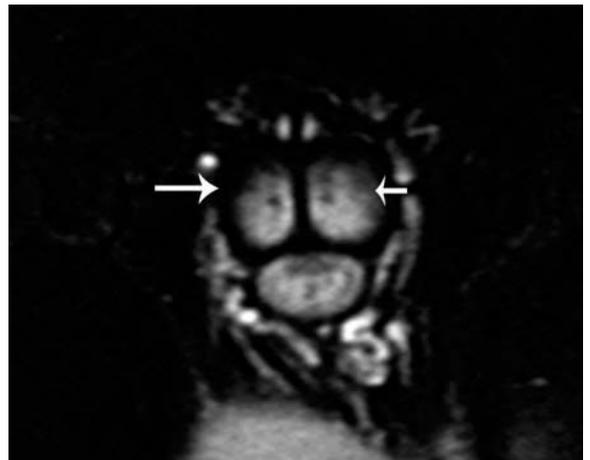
Normal penile anatomy in a 29-year-old male. Coronal T2-weighted image demonstrates the normal high T2 signal intensity of the penile corporal bodies (short arrow) and the normal lower T2 signal intensity of the surrounding tunica albuginea (long arrow).
